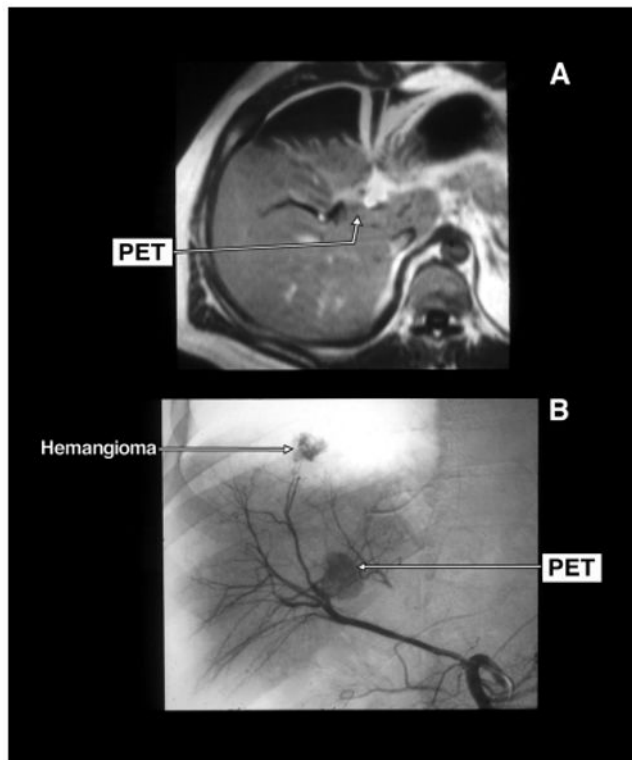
Gadolinium enhanced magnetic resonance imaging (MRI) (panel A) and selective arteriogram (panel B) of a pancreatic endocrine tumor (PET) that was in the wall of the right hepatic duct. The tumor was abutting the right portal vein. There is a second liver tumor shown on the hepatic arteriogram (panel B) as a liver hemangioma. The PET was locally resected with the right hepatic duct. The tumor was dissected off the portal vein.
